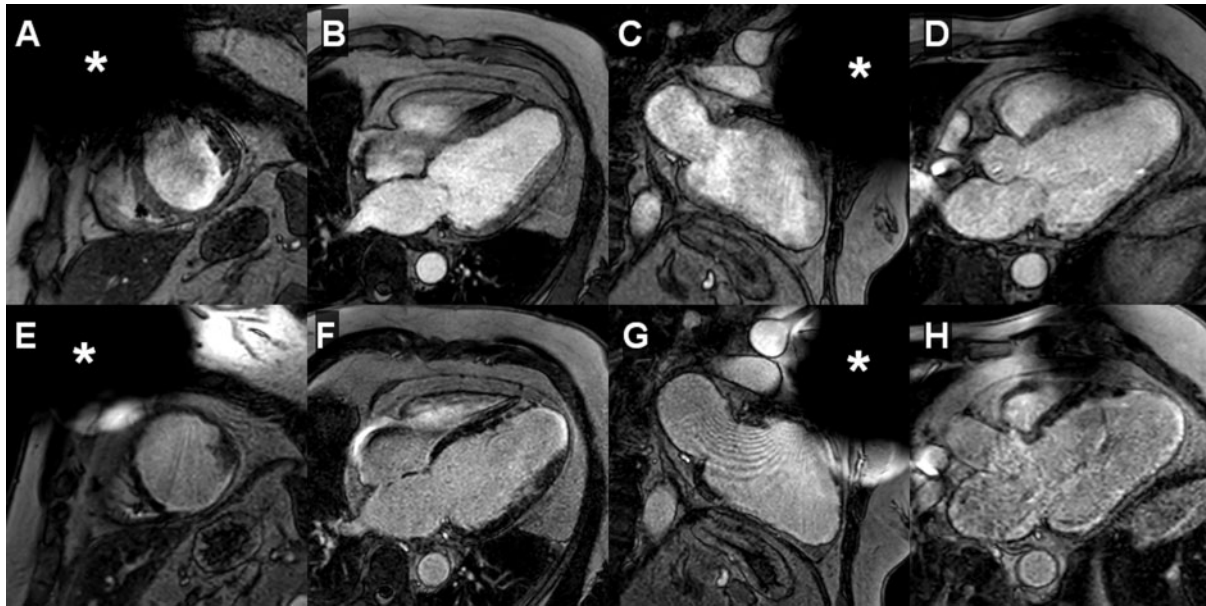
CMR examination in a device patient. CMR imaging data of a patient with left-sided single-chamber ICD who underwent basic functional cine and viability imaging for planning of coronary revascularization (intrinsic heart rhythm: sinus rhythm; antitachycardia therapy and pacing mode were switched off during the CMR examination). Spoiled gradient echo cine sequences were acquired in all cardiac standard geometries (i.e. short-axis and four-, two-, and three-chamber geometries) after application of a gadolinium-containing contrast agent (A–D); late-gadolinium enhancement (LGE) imaging was performed in identical scan geometries (E–H). Approximate device position (i.e. position of the ICD generator) is indicated by the asterisk. While image quality in anterior segments was moderately reduced, scan data still allowed for evaluation of the majority of left ventricular segments: transmural myocardial infarction of apical anterior and inferior segments as well as of the left ventricular apex together with extensive scar formation in all inferolateral left ventricular segments was identifiable. Hence, coronary revascularization in these coronary supply territories was deemed unsuitable. CMR, cardiac magnetic resonance imaging; ICD, implantable cardioverter-defibrillator.
